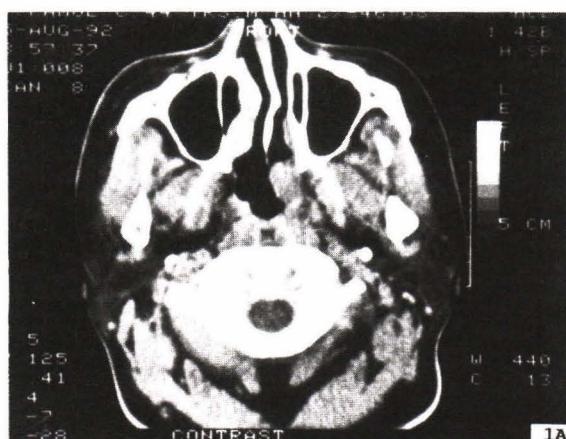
Tumor response to photodynamic therapy. A. An X-ray computed tomogram showing a residual tumor, diameter 3 cm, extending from left lateral wall of the nasopharynx into the nasal cavity. B. Three months after PDT, the tumor regressed almost completely. The treatment effect was classified as partial response since the treated site yielded a positive biopsy.
